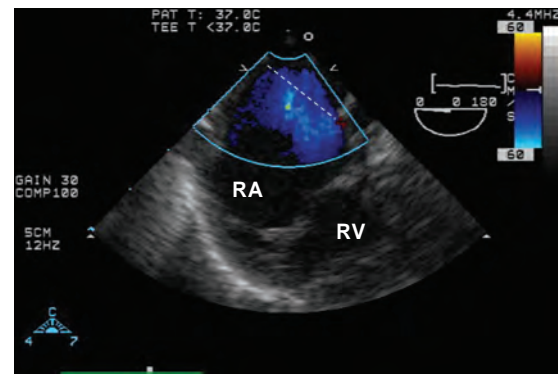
Midesophageal four chamber view at 0 degrees with color flow Doppler. There is a large volume left-to-right shunt (blue) across the atrial septal defect (ASD). The dashed line represents the approximate location of the ASD. The uniform blue color confirms low velocity flow through a large defect. RA, Right atrium; RV, right ventricle.
